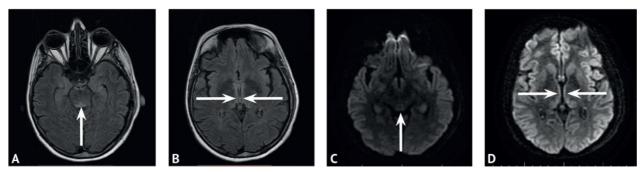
Magnetic resonance imaging of the brain of patient P. T2 FLAIR-images, axial sections: A — the arrow indicates the high signal area in the region of the quadrigeminal plate; B — symmetric areas of increased signal from the medial parts of the thalamus are specific for Wernicke encephalopathy; DWI-images, axial sections: C — the arrow indicates the area of weakly hyperintensive signal from the quadrigeminal plate, specific for Wernicke encephalopathy; D — arrows indicate the area of weak hyperintensive signal from the medial thalamus
